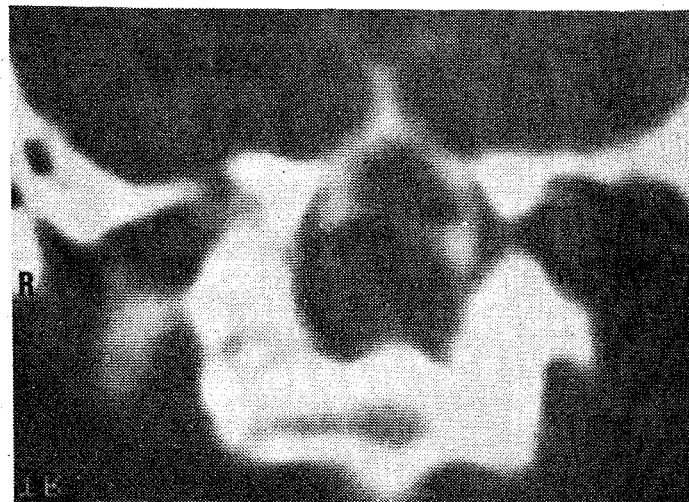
Axial CT-scan through C0/C1/C2.
